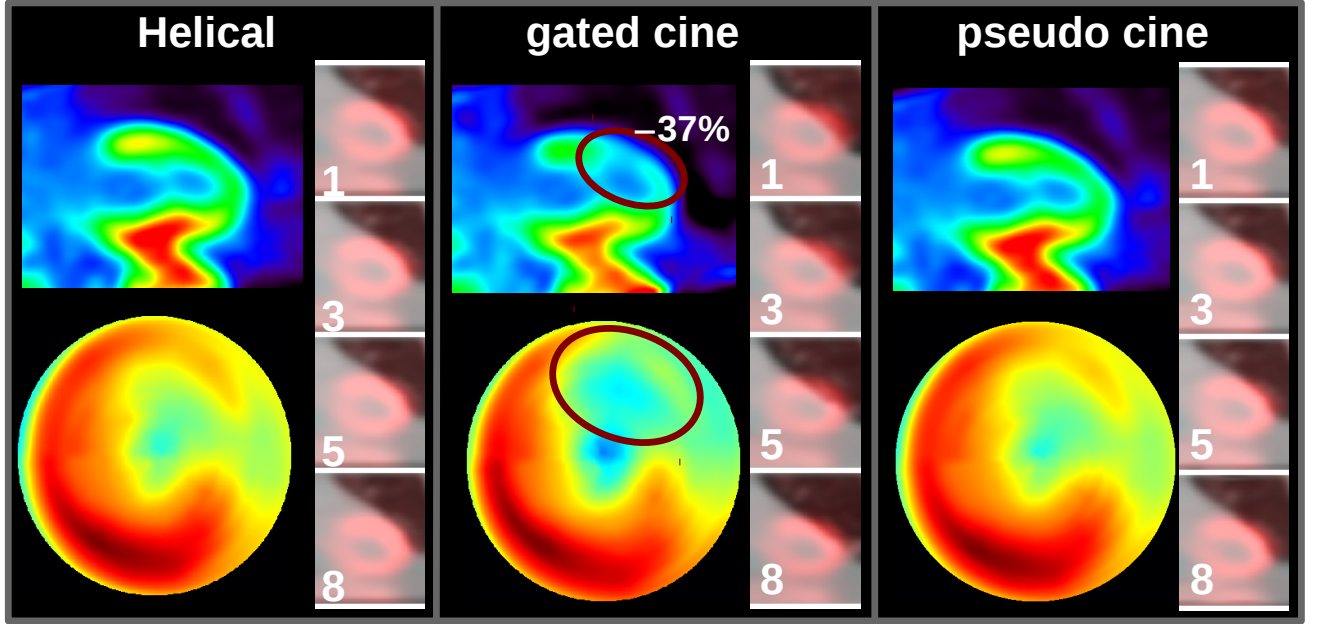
Cardiac PET-CT alignment is decreased from 0.3 mm with the helical CT to 11.5 mm with the gated cine CT. A 37% decrease in the anterior wall of the AC_{gated} AC PET images appears as a defect. Cardiac PET-CT alignment for the pseudo gated is 1.6 mm, and no anterior wall defect is seen.
